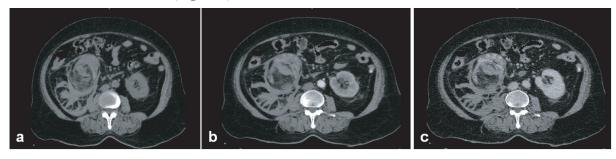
On axial images of the dynamic abdomen CT (a) Non-enhanced is revealed that the solid lesion filling the lower portion of the right kidney. There is also a huge retroperitoneal hematoma extending to the pelvis. (b) On arterial phase prompt arterial enhancement is not detected. (c) On the late phase; no wash- out is seen within the lesion.
